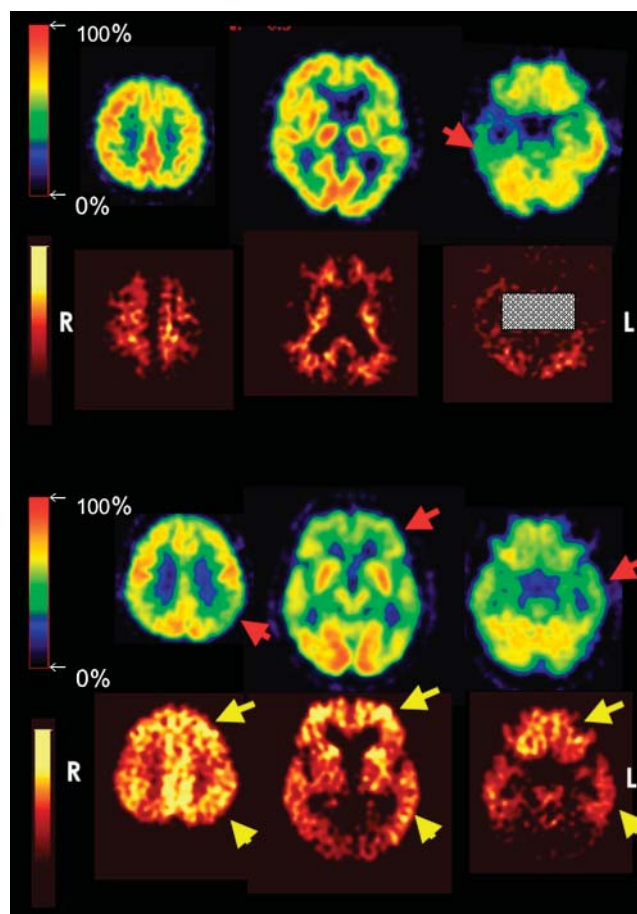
^{18}F -FDG PET and ^{11}C -6-OH-BTA-1 PET were used to assess cerebral glucose and cerebral amyloid plaques, respectively, in patients with semantic dementia (top 2 rows) and Alzheimer's disease (bottom 2 rows).
